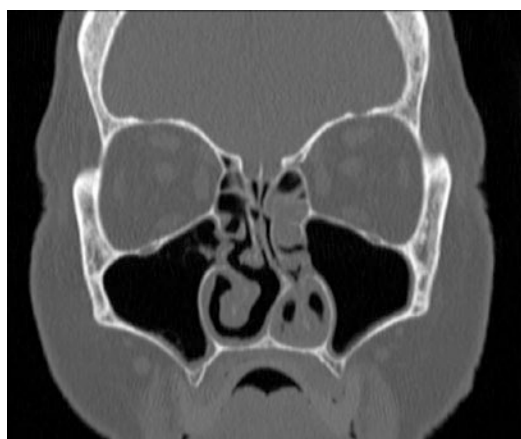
CT of the paranasal sinuses (coronal) demonstrating septal deviation to the left resulting in nasal obstruction and hypertrophy of the right inferior turbinate
